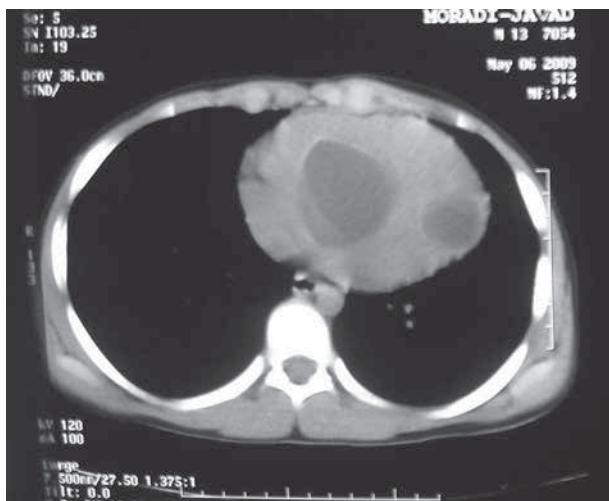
Thoracic CT Scan Demonstrating Cardiac Cysts
